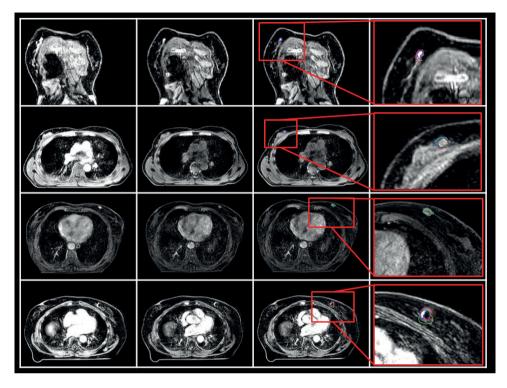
Example of four cases (A-D) in whom large interobserver variation was observed. In the first column MR images at approximately 5 minutes following contrast injection are shown without delineations, in the second column MR images at approximately 1 minute following contrast injection are shown without delineations, in the third column the same MR images at approximately 1 minute following contrast injection are shown with delineations by the different observers, in the fourth column these MR images and delineations are enlarged. A: Adjacent vessel (case 3, coronal plane); B: Background enhancement (case 4, transversal plane); C: Extended tumor spiculae (case 6); D: Biopsy marker close to tumor (case 10).
